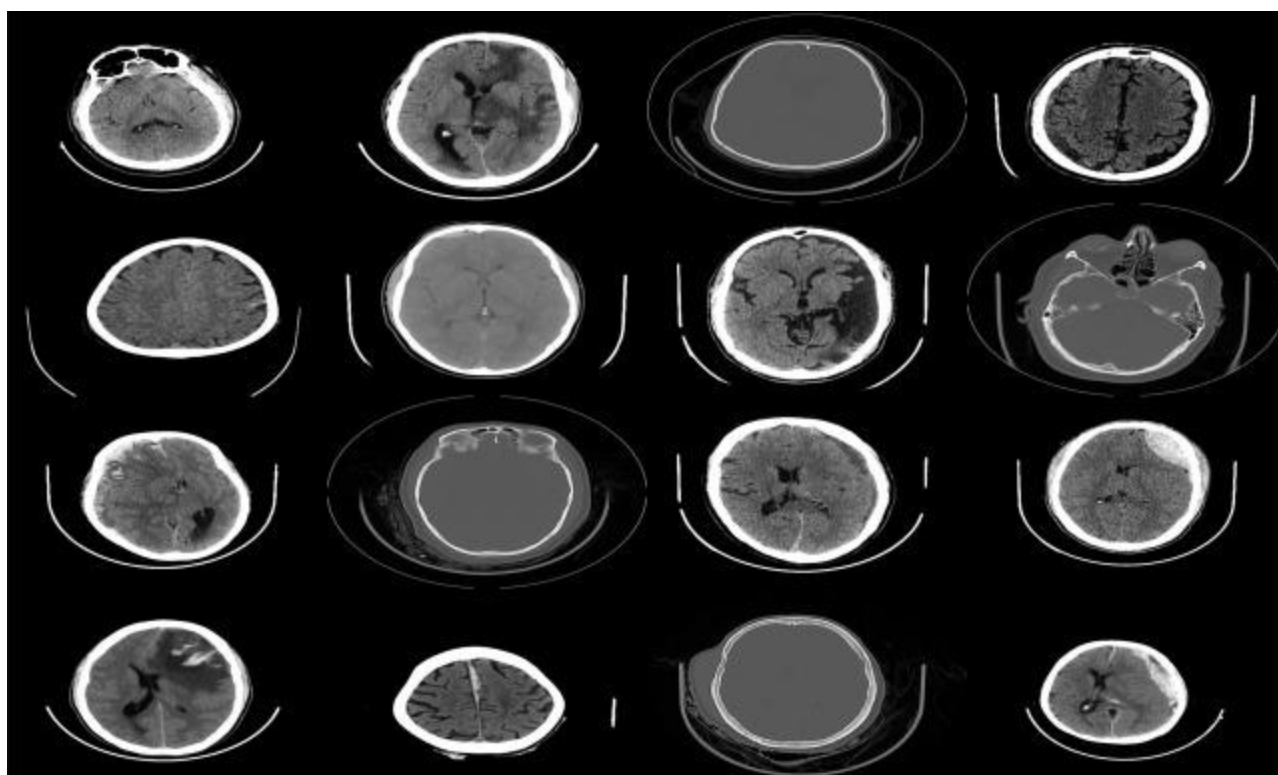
Sample test pictures from a medical dataset of brain CT scans.
